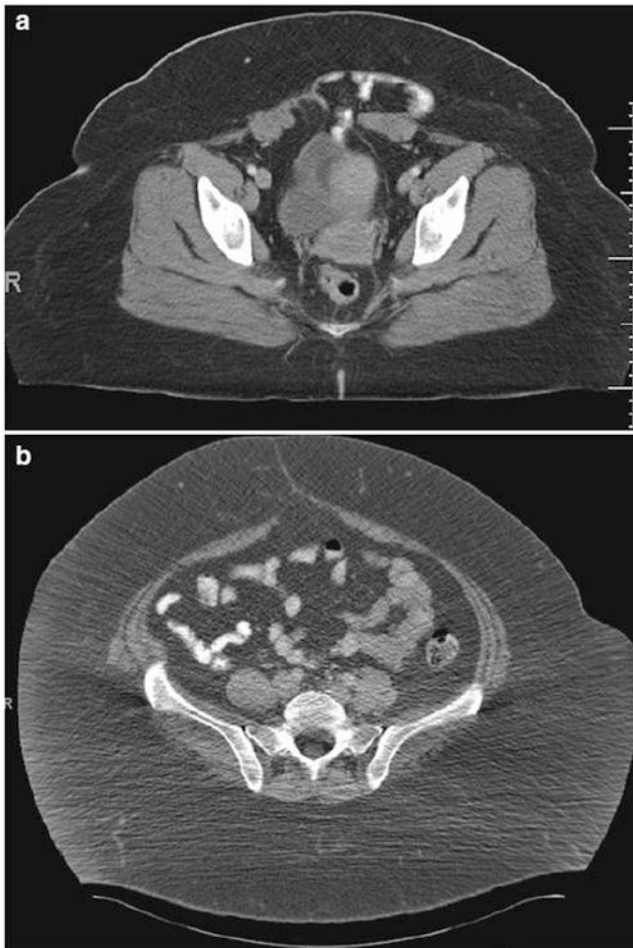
(a, b) A small incisional hernia in patients with a large body habitus is difficult to diagnose on physical examination, but it is clearly seen on CT
